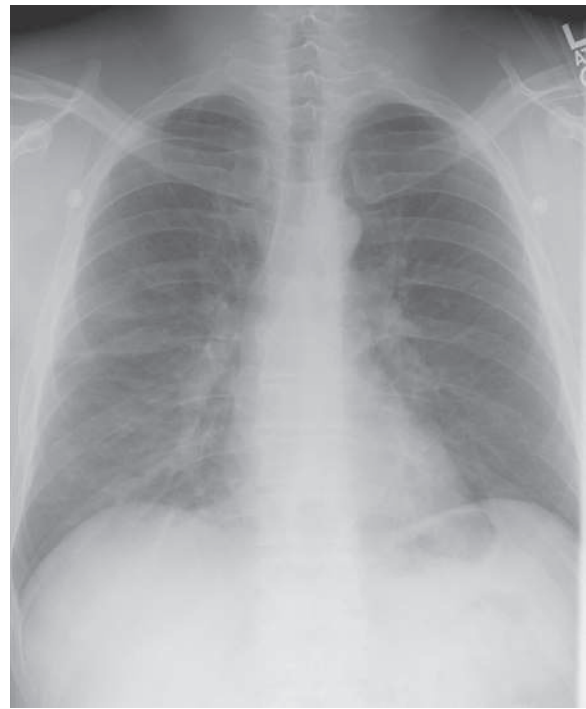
Chest radiograph of a diver with immersion pulmonary edema, showing bilateral patchy opacities consistent with pulmonary edema after an uneventful dive.
